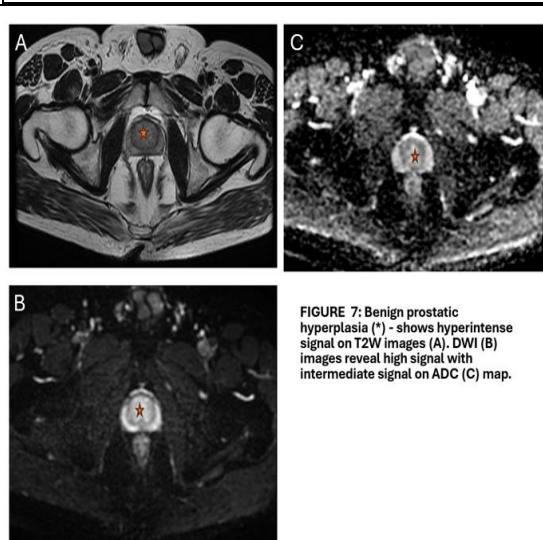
Benign prostatic hyperplasia (*) - shows hyperintense signal on T2W images (A). DWI (B) images reveal high signal with intermediate signal on ADC (C) map.
